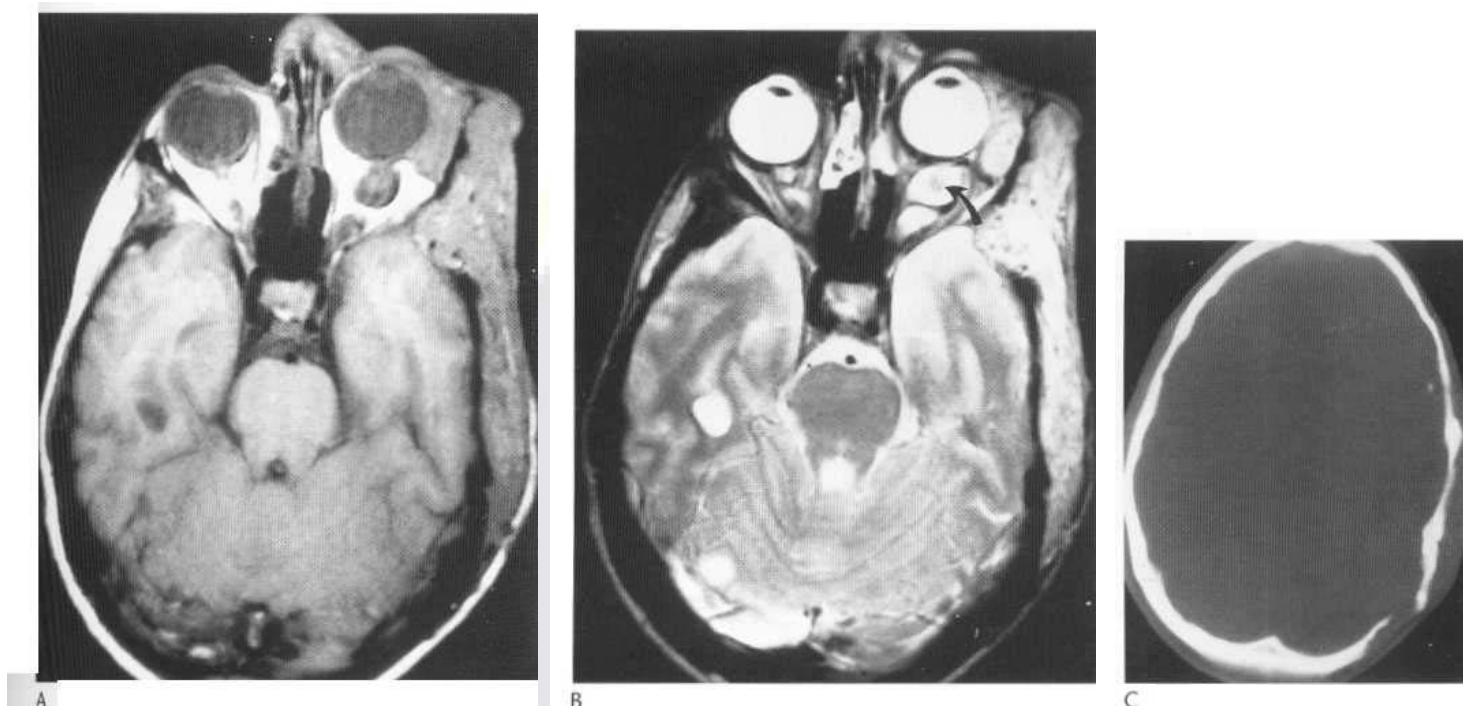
Plexiform neurofibroma. T_1 -weighted (A) and T_2 -weighted (B) MR images demonstrate extensive left temporal scalp lesion with extension to the left orbit resulting in mild [proptosis](#). [MR](#) also demonstrates ectatic left optic nerve (arrow). CT image at bone windows (C) demonstrates associated bony defect of left lambdoid suture.
